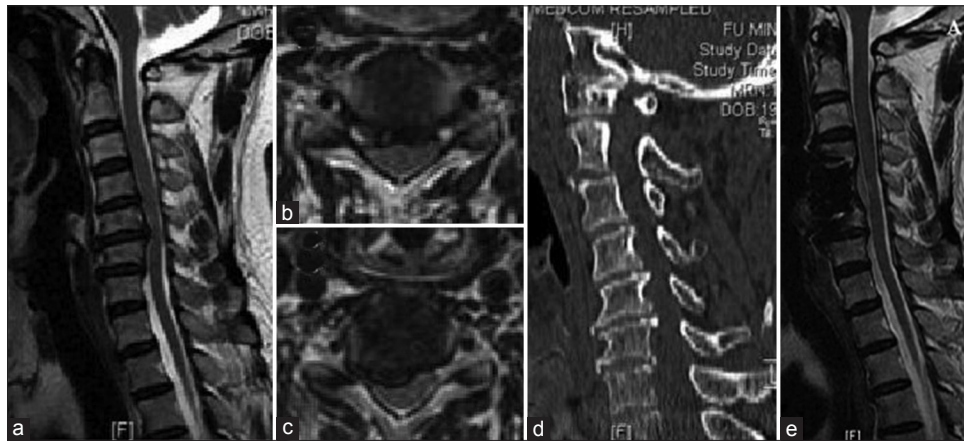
A 41 year old male patient who presented as proximal type and undergone anterior cervical decompression and fusion (ACDF). (a) The sagittal T2 weighted MRI showed that the spinal cord was compressed at C4-C5 and C5-C6 vertebral levels. (b) Axial T2 weighted MRI demonstrated that the cord was centrally compressed at C4-C5 disc level. (c) Axial T2 weighted MRI demonstrated that impingement against anterior horn at C5-C6 vertebral level. (d) Two dimension CT showed that the presence of cervical canal stenosis (e) Postoperative sagittal T2 weighted magnetic resonance image was obtained 1 year after surgery. It showed that adequate decompression of the cord behind the corpectomy levels with no compression at any other levels
